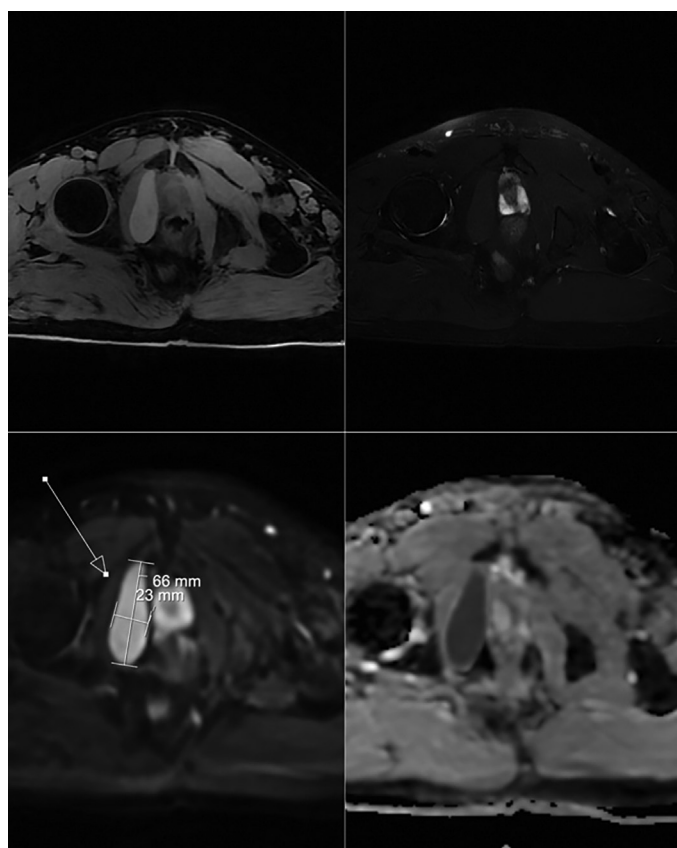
Axial T1 and T2 magnetic resonance imaging shows an infected cystic lesion 66x23 mm with T1A hyperintense, T2A hypointense, diffusion restriction in the right posterolateral near the bladder at the level of the obturator
